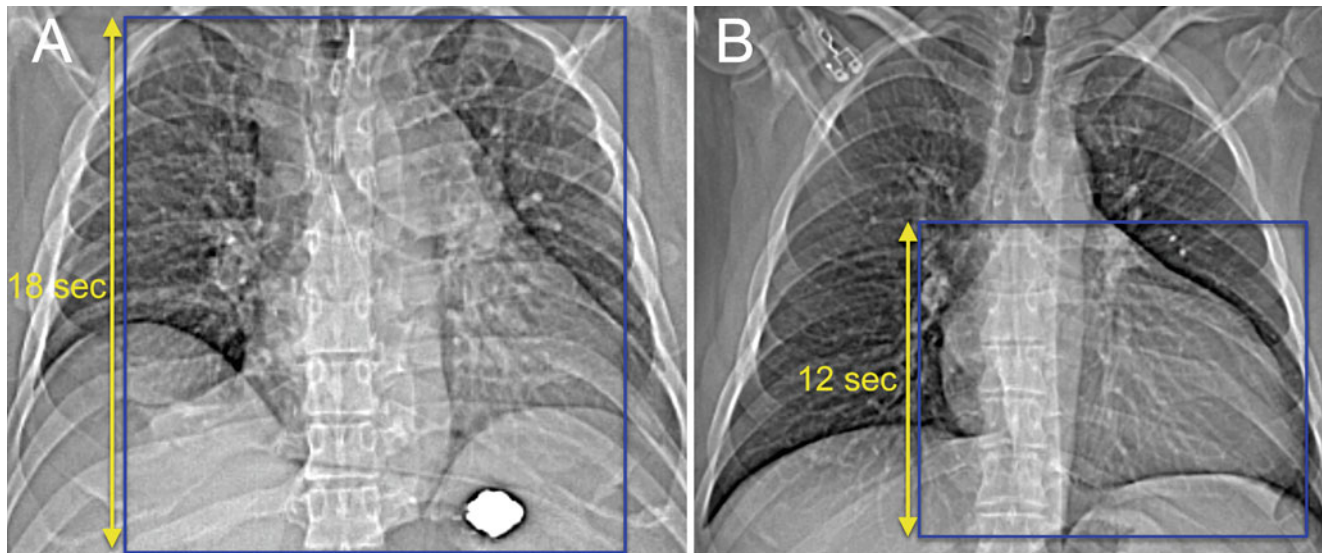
(a) Topogram of a pulmonary vein study is notable for an expiratory breath-hold. The scan coverage for the contrast-enhanced CT is highlighted in the *blue box* and should range from the aortic arch vessels to the diaphragm. The scan coverage time can be multiplied by the rate of contrast infusion to obtain the estimate total contrast volume
